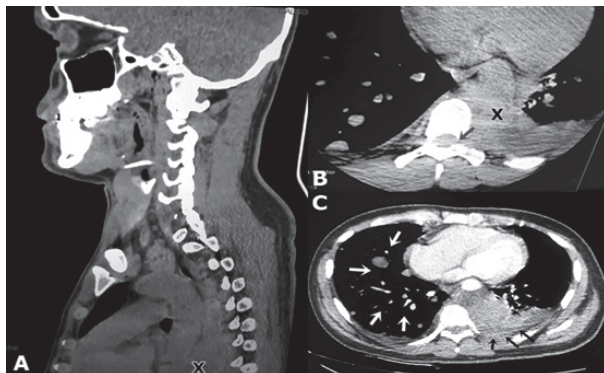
Computed tomography of the patient performed at HOL. A: Sagittal plane evidencing the paravertebral muscle and tumoral mass represented by X black; B: pyramidal invasion evidenced by black arrow and tumoral mass evidenced by X black; C: axial plan evidencing pulmonary metastatic nodes (white arrows) and pleural stroke (black arrows)
